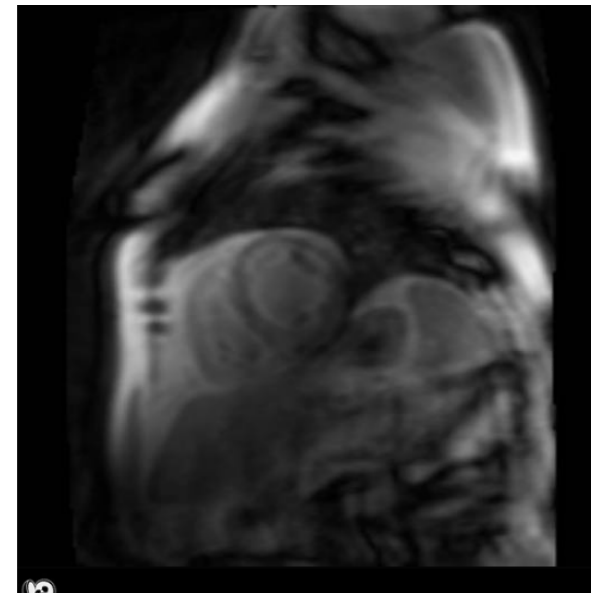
Pulmonary and systemic arterial flow determination by phase contrast magnetic resonance imaging in a 17 year old patient with partial anomalous pulmonary venous connection. (A) Coronal positioning scan for aortic acquisition, showing position of aortic phase contrast section. (B) Magnitude image from aortic phase contrast section. (C) Corresponding phase image from aortic section. (D) Sagittal positioning scan for pulmonary acquisition, showing position of pulmonary phase contrast section. (E) Magnitude image from pulmonary phase contrast section. (F) Corresponding phase image from pulmonary section. (G) Calculated systemic and pulmonary flow rates. Calculated  $Q_p:Q_s$  ratio was 2.17:1.
